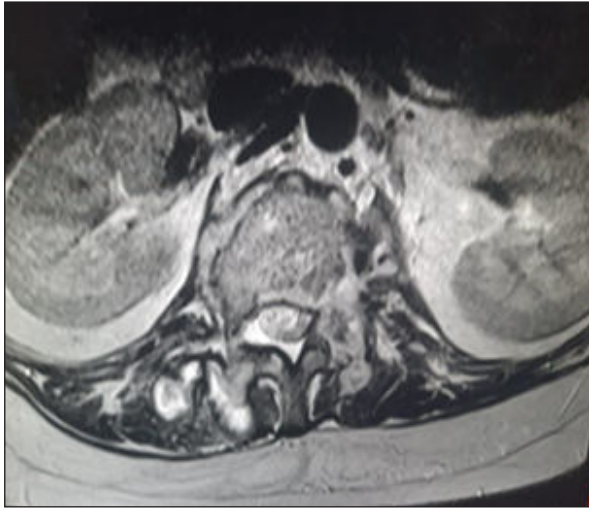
Thoracolumbar Involvement MRI Axial Sections : Vertebral Body Destruction With End plate Involvement .
